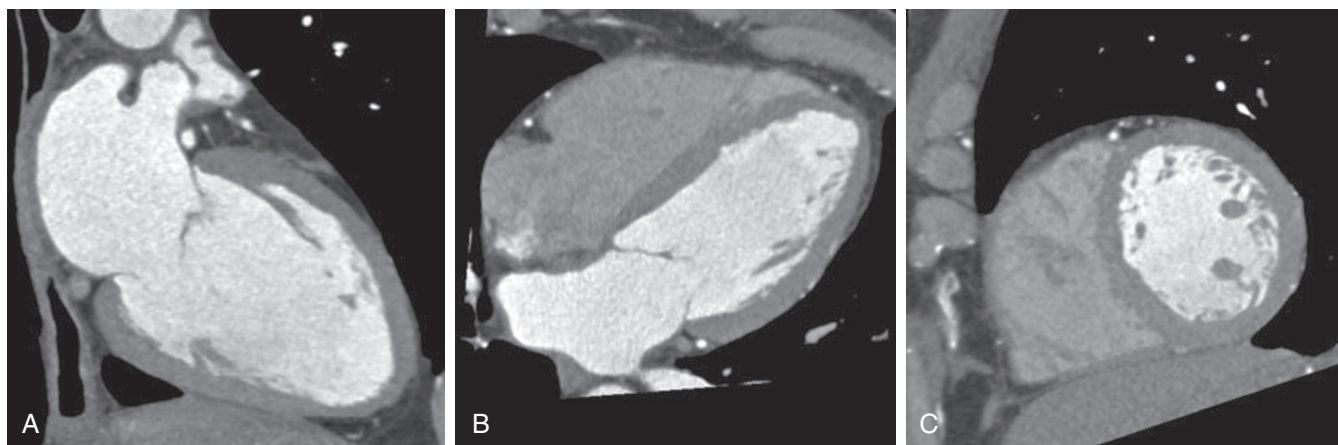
Standard cardiac chamber axes on cardiac CT including two-chamber (A), four-chamber (B), and short-axis (C) views. Contrast timing in this study shows a typical level phase (right side of the heart is underfilled with contrast) in diastole (mitral valve is in the open position).
